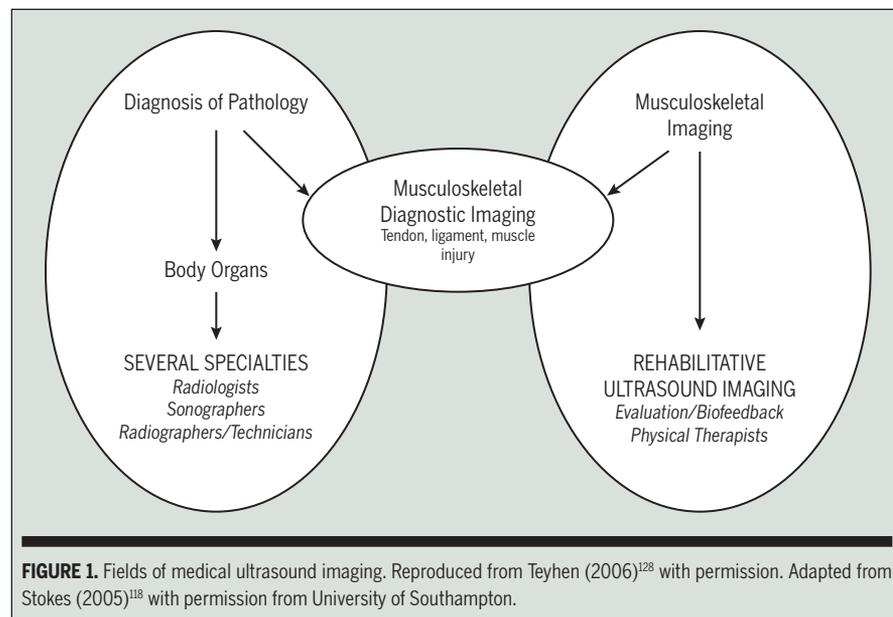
Fields of medical ultrasound imaging. Reproduced from Teyhen (2006)¹²⁸ with permission. Adapted from Stokes (2005)¹¹⁸ with permission from University of Southampton.
